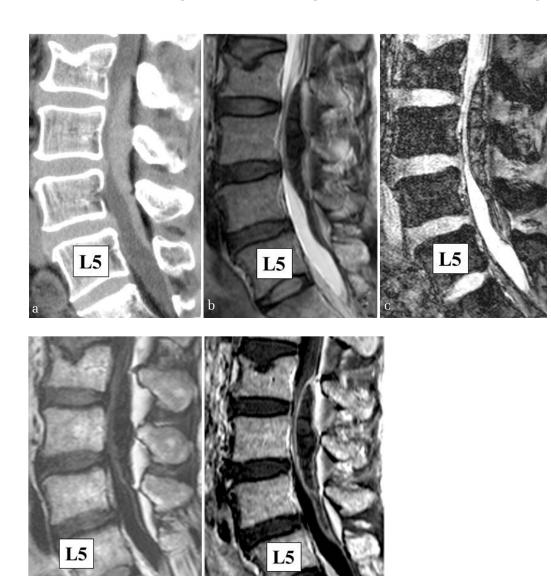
Preoperative CT (a) and MR images (b: T2, c: T2*) on sagittal view.
